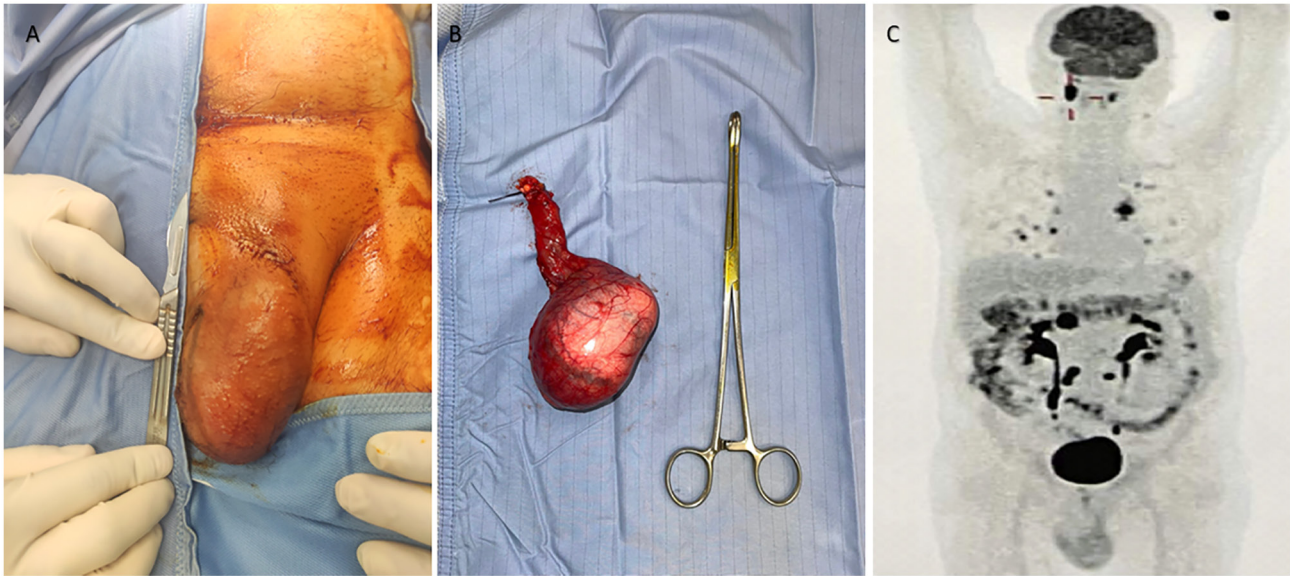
(A) Testes before surgery. (B) Testes removed. (C) PET/CT scan after surgery. PET/CT, positron emission tomography-computed tomography.
